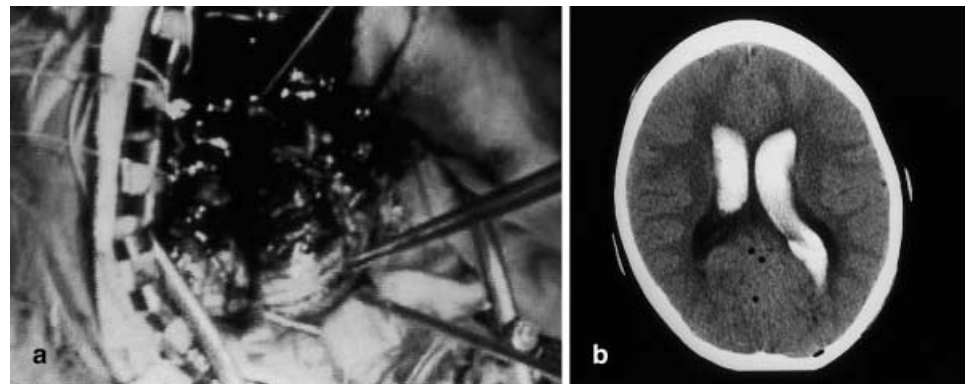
a Intraoperative findings. The cerebellum was bulging progressively from immediately after dural incision and ligation of the occipital sinus. b Postoperative CT revealing intraventricular hemorrhage
